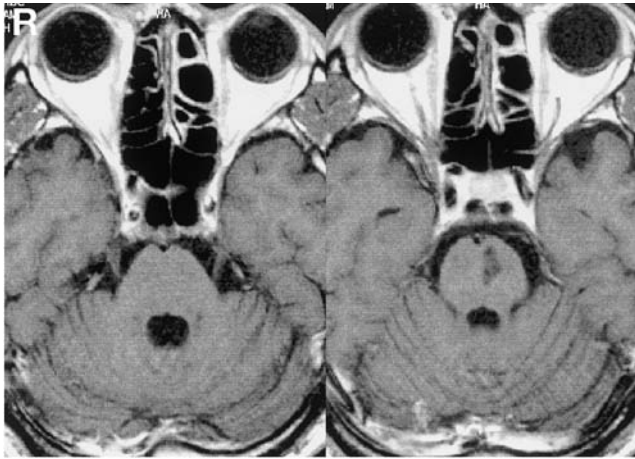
Axial T₁-weighted magnetic resonance images with gadolinium 6 months after the onset showing the remarkably decreased mass surrounding the basilar artery.
